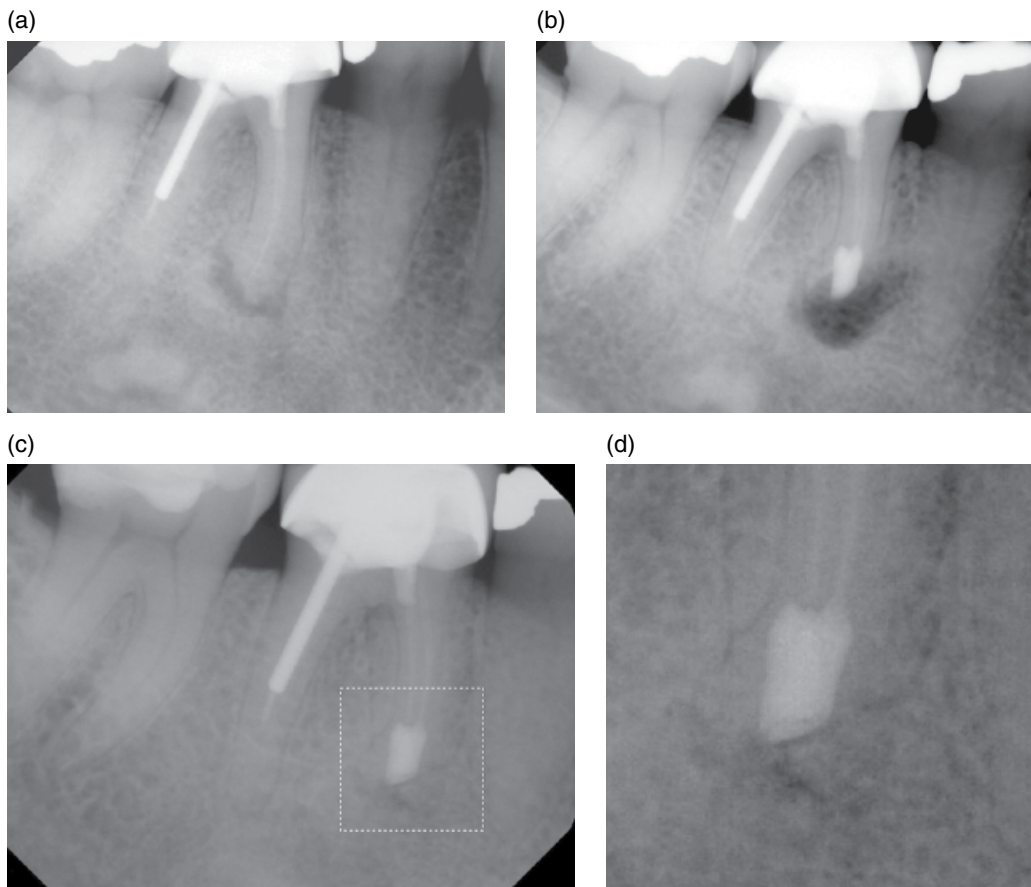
Outcome evaluation using conventional 2-dimensional radiography after surgery on mesial root of a first right mandibular molar. (a) Preoperative radiograph. (b) Postoperative radiograph. Note isthmus preparation and root-end filling in situ (RRM). (c) 12-months follow-up, radiographic healing observed, no clinical symptoms. (d) Close-up of marked area in (c). Note radiographic re-establishment of periodontal ligament outline and osseous healing in the periradicular area. Courtesy of Dr Frank Setzer, Philadelphia, PA, USA.
